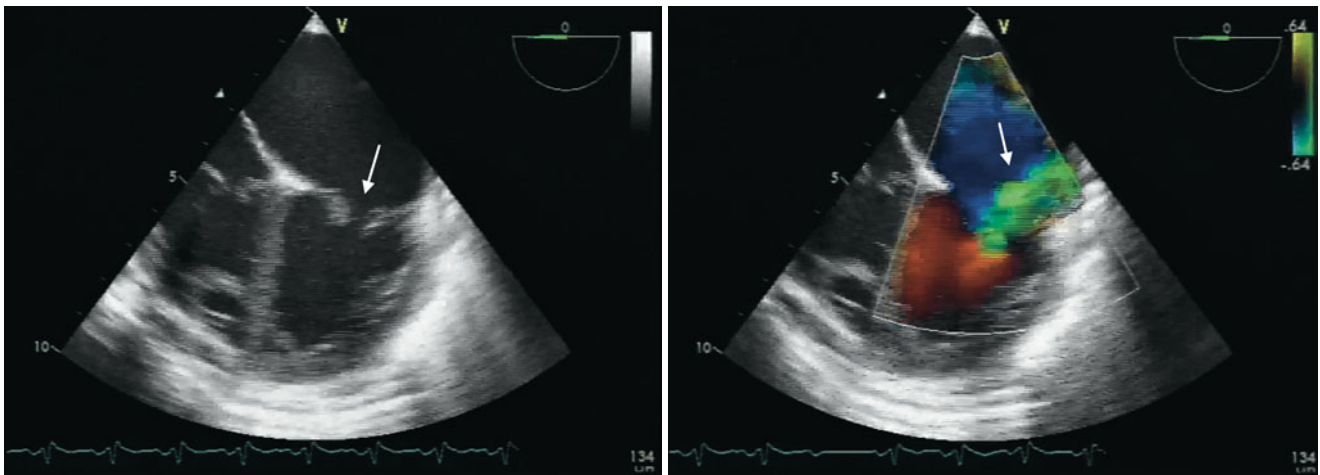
Left panel*, mid esophageal four chamber view depicting a thickened mitral valve with lack of systolic coaptation (*arrow*) in infant with congenital mitral regurgitation. *Right panel*, color flow Doppler
